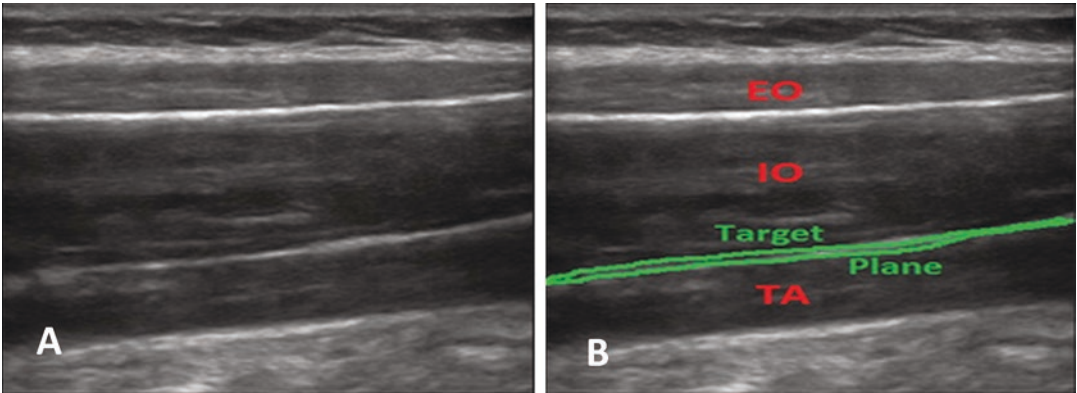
TAP ultrasound anatomy and target, unlabeled (a) and labeled (b). The goal is to place needle tip into target plane and “peel” fascial layers apart with local
